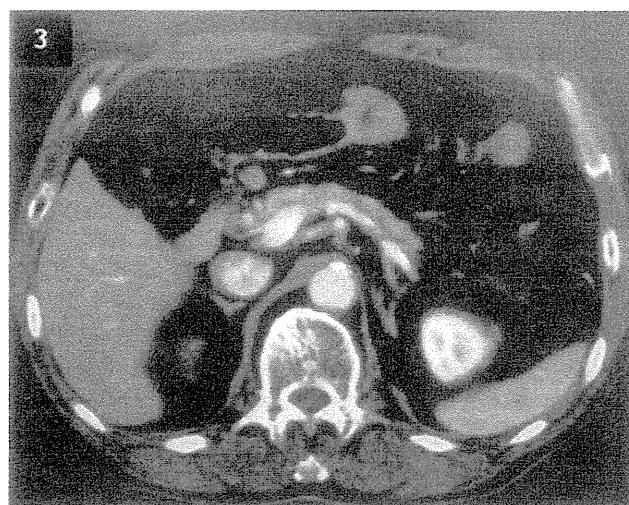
Computed tomography revealed multiple lymph node metastases around stomach.
